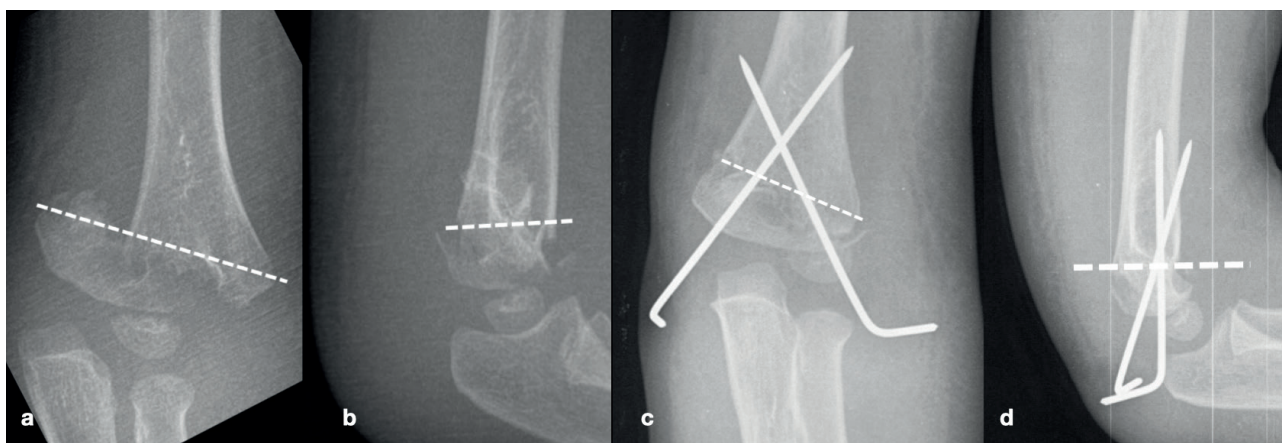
a) Anteroposterior (AP) and b) lateral elbow radiographs demonstrating 3 years old girl with low fracture. c) AP and d) lateral radiograph after K wire fixation with 1 medial 1 lateral pin construct.
